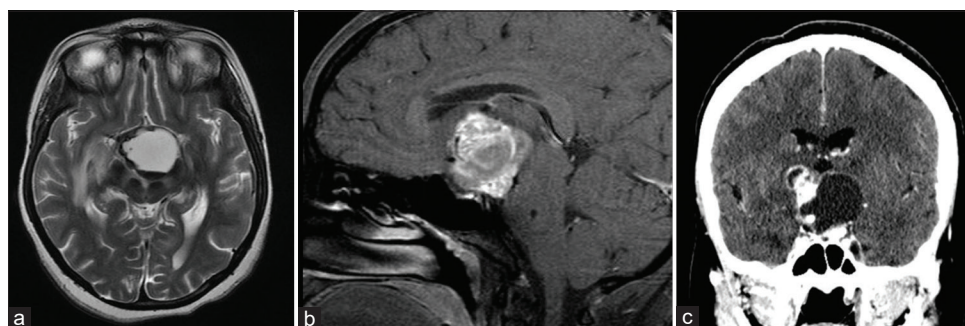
Axial magnetic resonance imaging (MRI) T2 (a) sagittal MRI T1 with contrast (b) and computed tomography (CT) coronal view (c) revealing a large cystic lesion with solid component occupying the suprasellar region exerting mass effect on the surrounding neurovascular structure CT image is showing the calcification component of the lesion.
